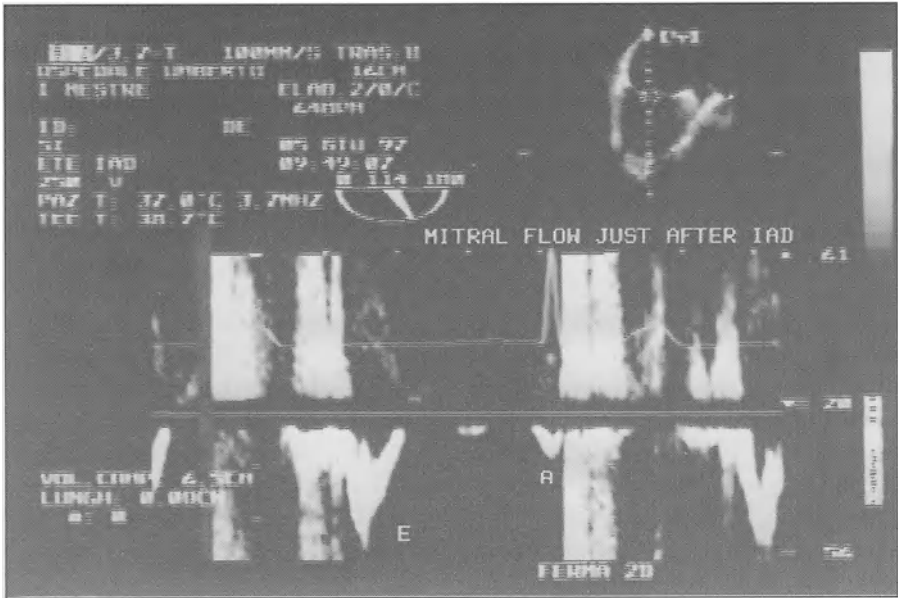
Doppler analysis of mitral flow velocity recorded a few seconds after the restoration of sinus rhythm. The atrial stunning is expressed by the low velocity of forward flow during atrial contraction (A)
